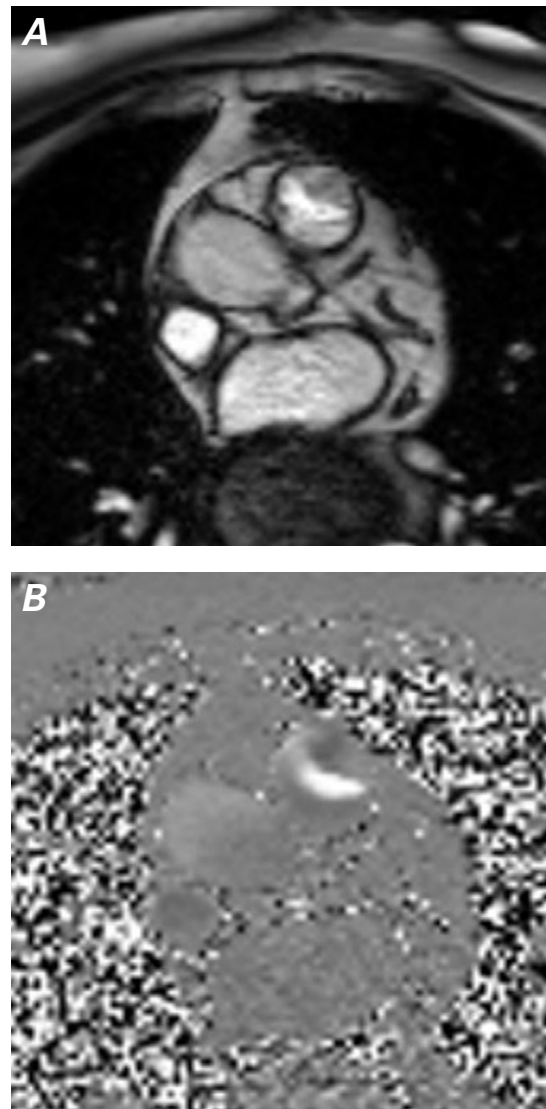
Cardiac magnetic resonance images. A) Steady-state free precession sequence shows the opening of the bicuspid pulmonic valve. B) Phase contrast sequence shows a crescent-shaped flow pattern across the valve.
